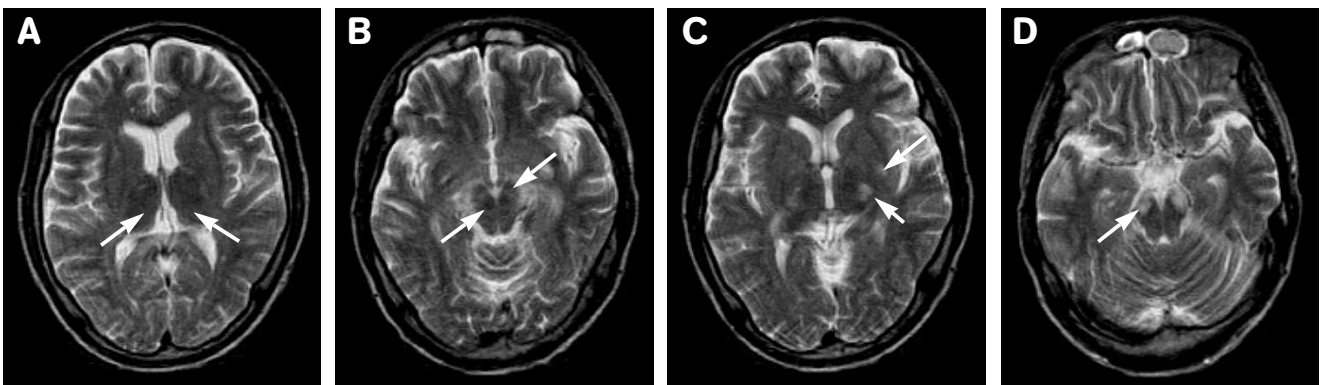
Axial brain MR images of a 33-year-old man who abused toluene. T2-weighted images show slight hypointensity bilaterally in the thalamus (arrows in A), red nucleus (short arrow in B) and substantia nigra (long arrow in B), and asymmetrically increased signal intensity of posterior limbs of internal capsule and thalamus (short arrow in C), left putamen (long arrow in C), and crus cerebri of midbrain (arrow in D).
